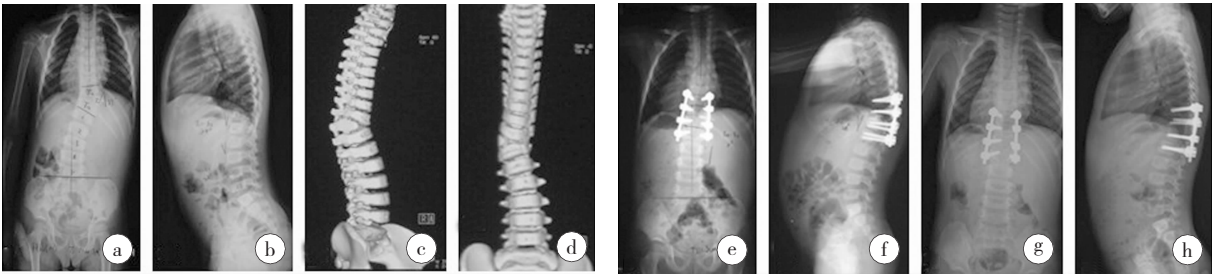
患儿, 女, 3 岁, 先天性脊柱侧凸, T11 完全分节半椎体。a、b、c、d 为术前全脊柱 X 光片及 CT 三维重建片, 冠状面节段性侧凸 34° , 矢状面节段性后凸 29° 。接受后路 T11 半椎体切除、内固定、植骨融合术。e、f 为术后全脊柱 X 光片, 冠状面节段性侧凸 0° , 矢状面节段性后凸 20° 。g、h 为术后 3 年随访, 冠状面节段性侧凸 5° , 矢状面节段性后凸 22° 。
